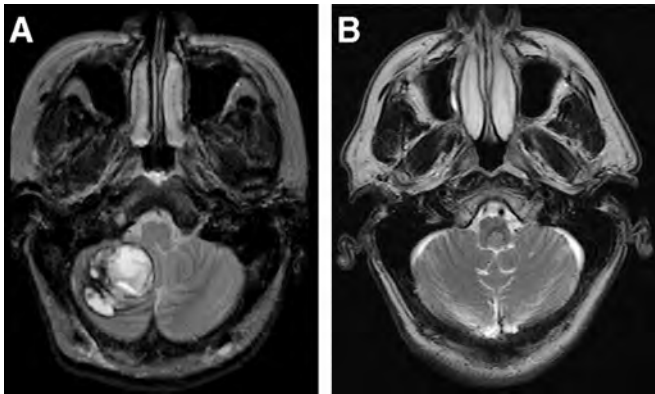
Axial T2-weighted MRIs of two patients referred for radiosurgery that were not acceptable candidates. *A*, A 29-year-old woman with acute onset of headache and ataxia. MRI shows a right cerebellar hemorrhage from a cavernous malformation. The patient was symptomatic from this surgically accessible lesion and resection was performed without incident. *B*, A 72-year-old man with dizziness. MRI shows cavernous malformation on the floor of the fourth ventricle. Without a history of hemorrhage, observation was recommended.
